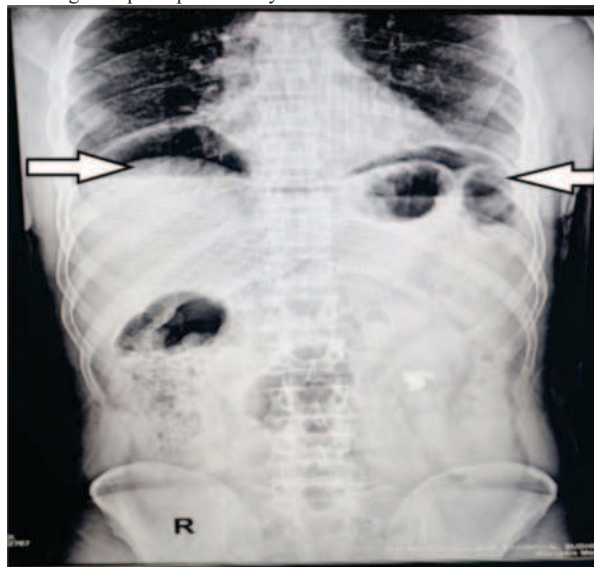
Xray abdomen showing b/l air under diaphragm
